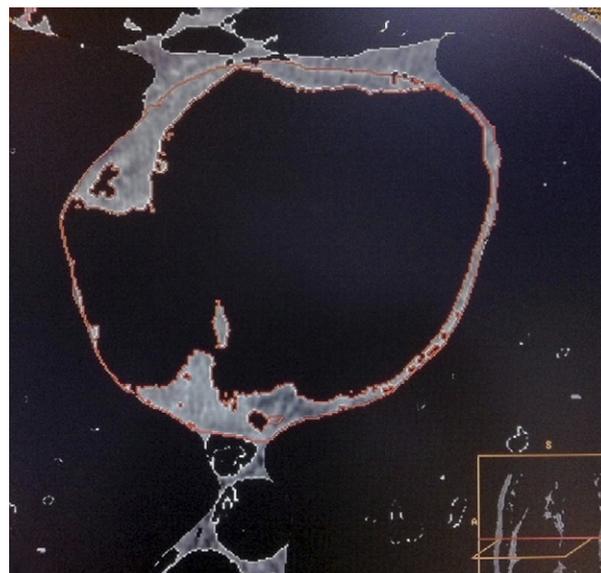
Example of Epicardial Adipose Tissue Extraction From Computed Tomography Images
